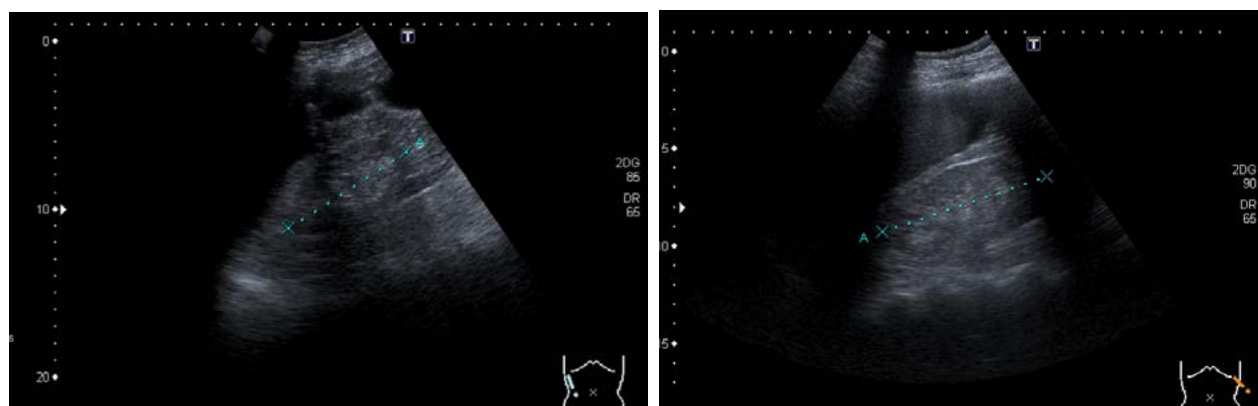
Kidney ultrasound showing bilaterally reduced kidney size, increased parenchymal echogenicity, and loss of corticomedullary differentiation.
